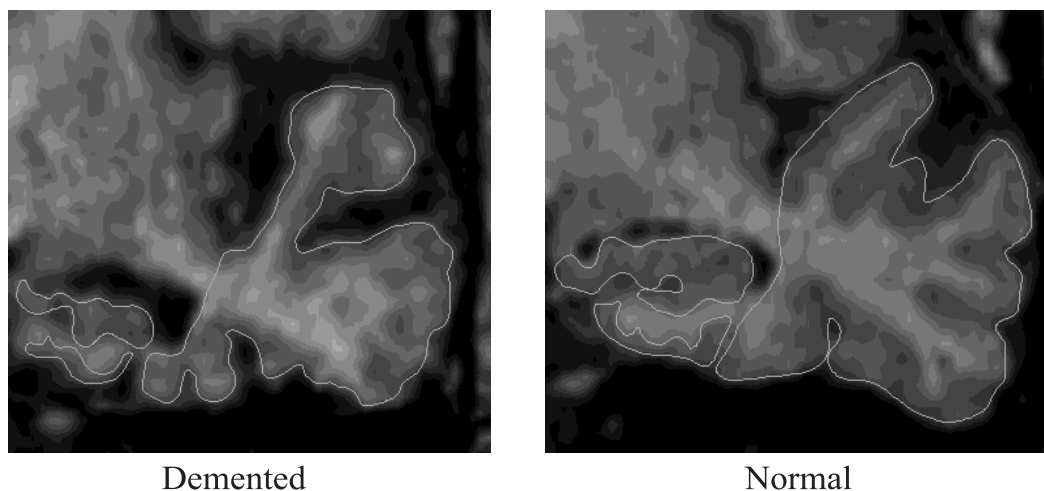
Example VOI tracings on T1-weighted MR images for two individuals classified as demented (left panel) and normal (right panel). VOIs traced were the hemispheric regions of the hippocampus (HC, middle left in panels), parahippocampal gyrus (PHG, lower left), and remaining temporal lobe (TL; which excluded the HC, PHG and white matter of the PHG).
